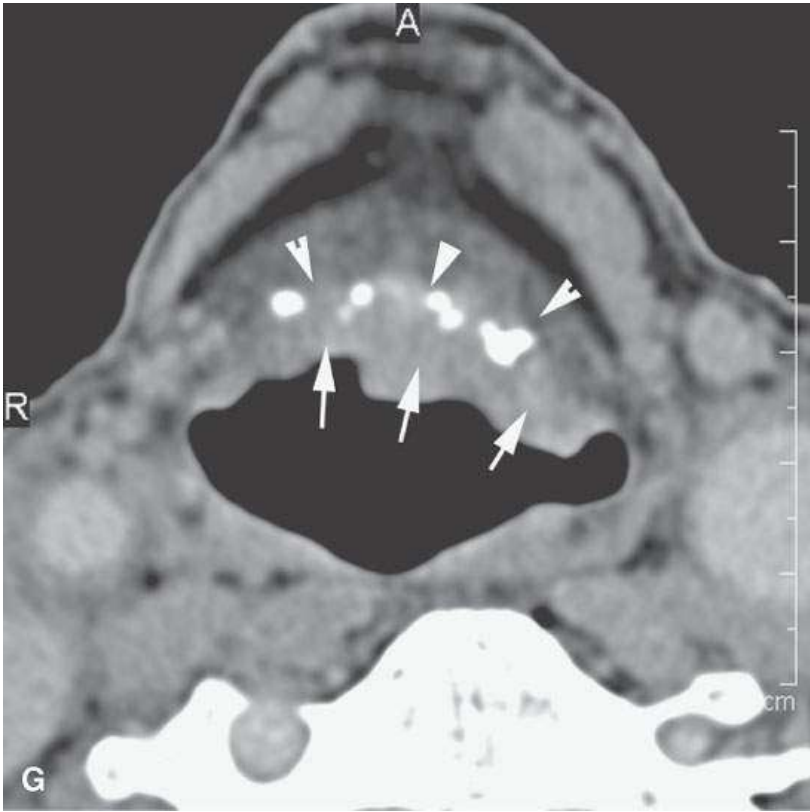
Two patients with carcinomas of the infrahyoid epiglottis A–E: Contrast-enhanced computed tomography (CECT) study in Patient 1 with deeply infiltrating carcinoma of the infrahyoid epiglottis. In (A), the tumor is endophytic nearly entirely and filling the pre-epiglottic space. In (B), the tumor ended well above the anterior commissure, and the patient was suitable for supraglottic laryngectomy. In (C), the patient elected radiotherapy (RT). A baseline study done about 3 months after the completion of RT showed little response of the tumor (C). In (D), the persistent tumor still ended well above the anterior commissure, so the patient was suitable for supraglottic laryngectomy. In (E), the patient status post supraglottic laryngectomy shows gross total resection. The patient was cured. F, G: CECT study of Patient 2 with an exophytic plaque-like lesion of the infrahyoid epiglottis to contrast with the lesion in (A) through (E). In (F) and (G), at the junction of the infrahyoid and suprahyoid epiglottis, there is plaque-like tumor along the laryngeal surface (arrow). There is minimal invasion of the pre-epiglottic space through the calcified epiglottic cartilage (arrowhead). G: Somewhat more inferiorly the tumor spread along the infrahyoid epiglottis is mainly exophytic. There is no significant penetration of tumor through the calcified epiglottic cartilage into the preepiglottic space (arrowheads). (Note: This second cancer was very suitable for supraglottic laryngectomy or radiation cure. The patient had severe lung disease and was radiated and cured.)
